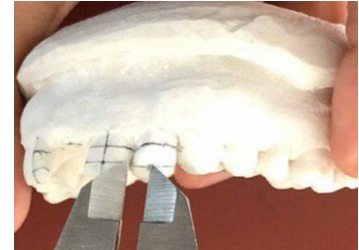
Radiograph showing root canal filling Figure 3. Cast fabricated
